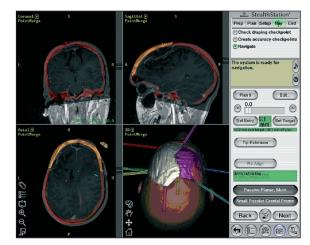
Neuronavigator implementation of the patient's magnetic resonance data with computed tomography scan of the three-dimensional model of the patient's cranium. The cranial prosthesis has been marked out (in two pieces, in this particular case) for a neuronavigator-assisted surgical demolitionreconstruction procedure
